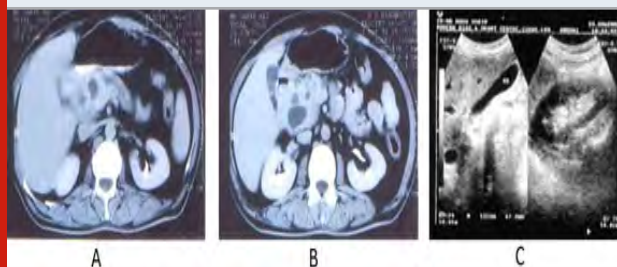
Treatment of pancreatic tumor with polyherbal therapy HUMA A & B- CT scan at presentation; C- USG after 5 years
